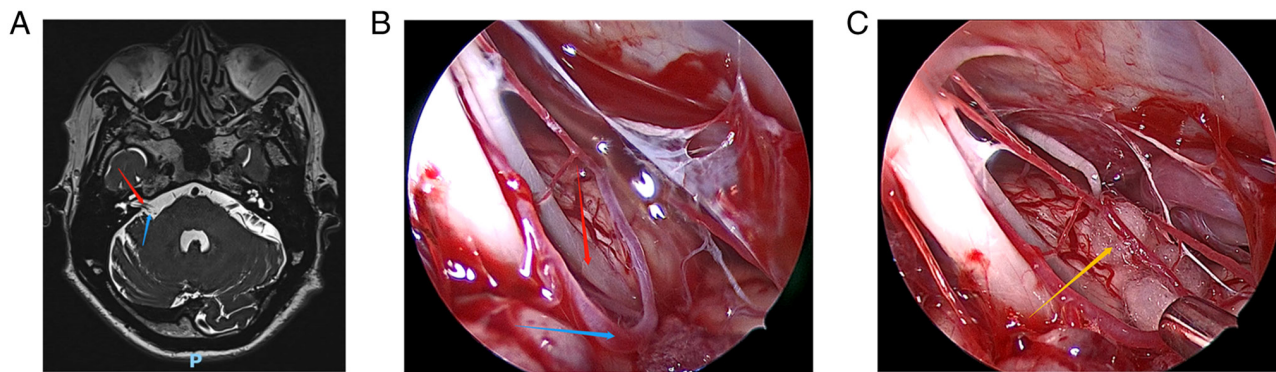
Patient 5. (A) Preoperative head magnetic resonance imaging of the patient. (B) The the anterior inferior cerebellar artery and compressed cranial nerves were clearly visible under the endoscopic view. (C) The Teflon pad was placed between the root exit zone of cranial nerve 7 and the anterior inferior cerebellar artery under the endoscopic view. Red arrows indicate the compressed cranial nerve vessels, blue arrows indicate the anterior inferior cerebellar artery and the yellow arrow indicates the Teflon pad.
